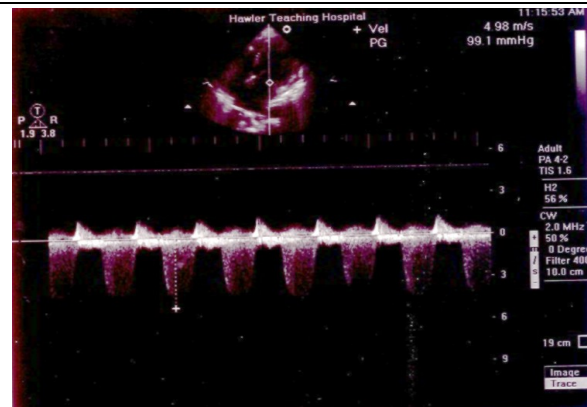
Continuous Wave Doppler recording from a patient with severe MR. Note the dense signal density, PG=99mmHg, velocity=4.98m/s.
